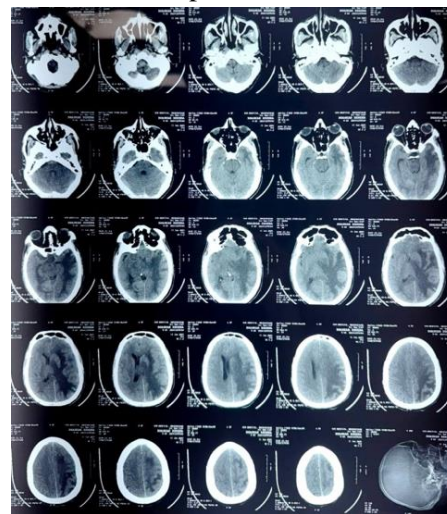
CT Brain axial slice shows the lesion and associated edema in a 76-year-old woman with lung cancer that has metastasized to the brain.
